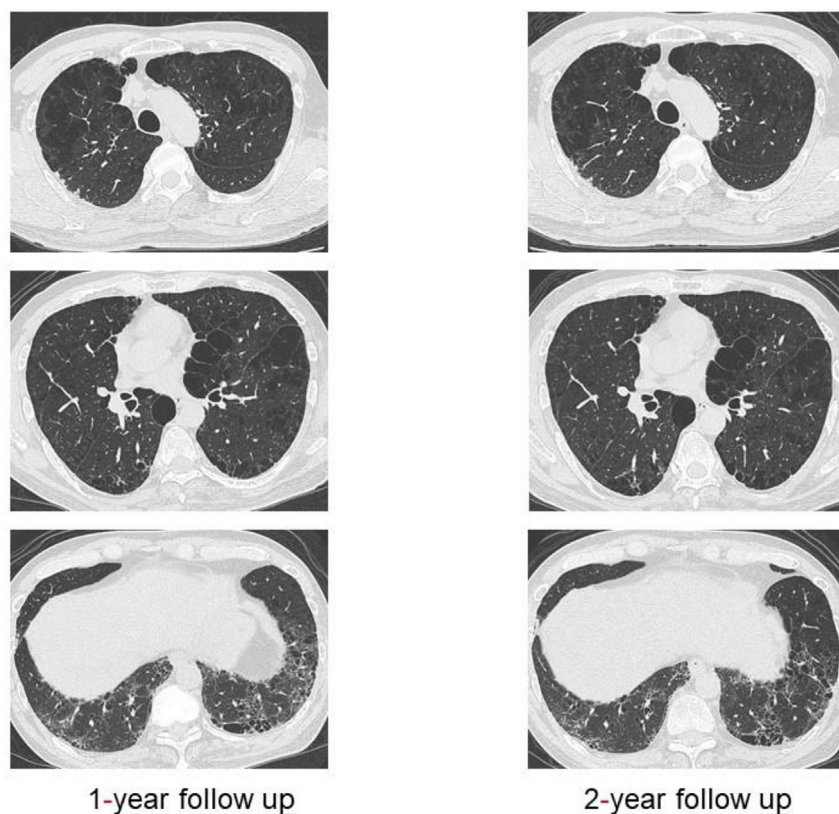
No obvious change in chest CT after the 1- and 2-year follow-up examinations.
